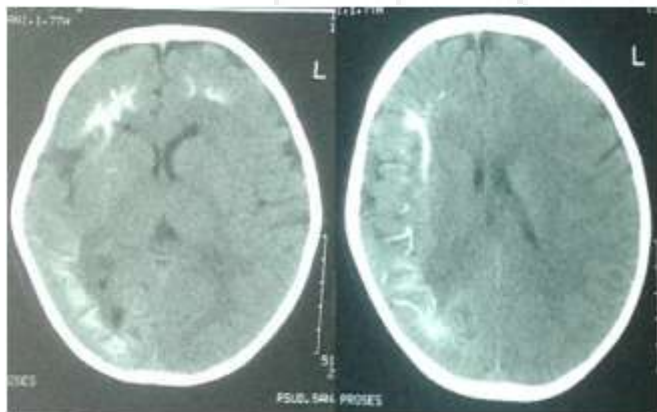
CT scan revealed calcification on leptomeninges in intra-axial right and left frontal lobe and right temporo-occipito-parietal lobe
